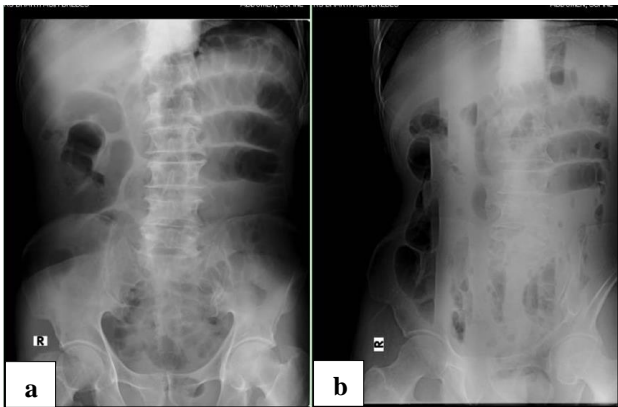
Plain abdominal radiography (a) supine position, and (b) LLD.
